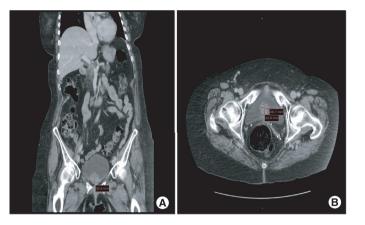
CT intravenous pyelogram (coronal and axial views) of polypoid urinary bladder mass. (A & B) CT intravenous pyelogram (coronal and axial views) showing polypoid soft tissue mass at the lower aspect of the urinary bladder measuring $3.3 \times 3.1 \times 2.4$ cm compatible with the biopsy-proven malignant melanoma.
